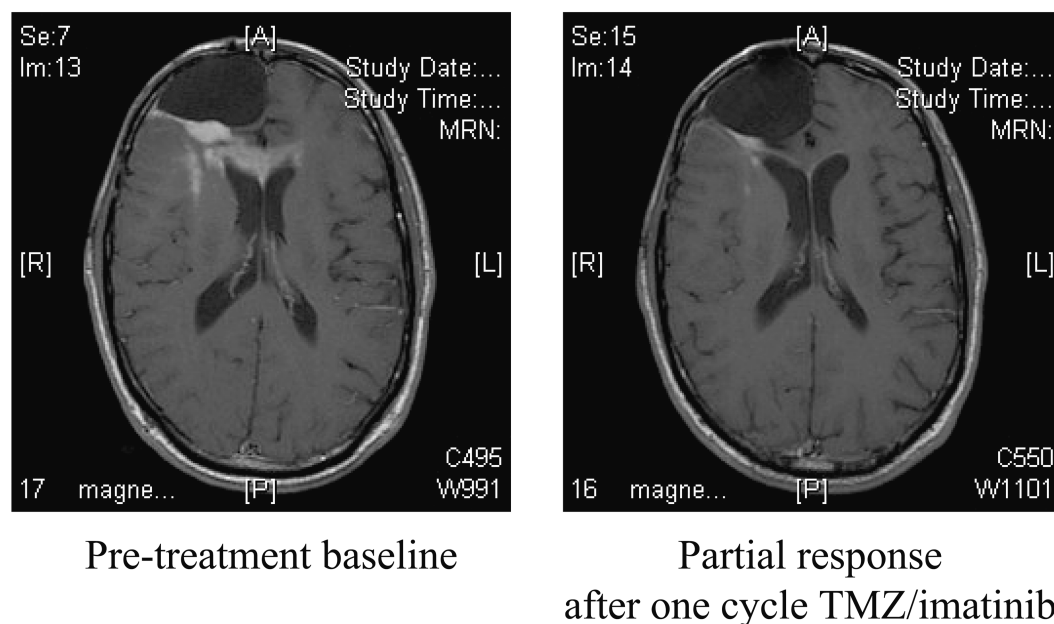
Representative radiographic partial response to temozolomide (TMZ) plus imatinib in a patient with recurrent GBM (T1-weighted MRI after gadolinium administration).
